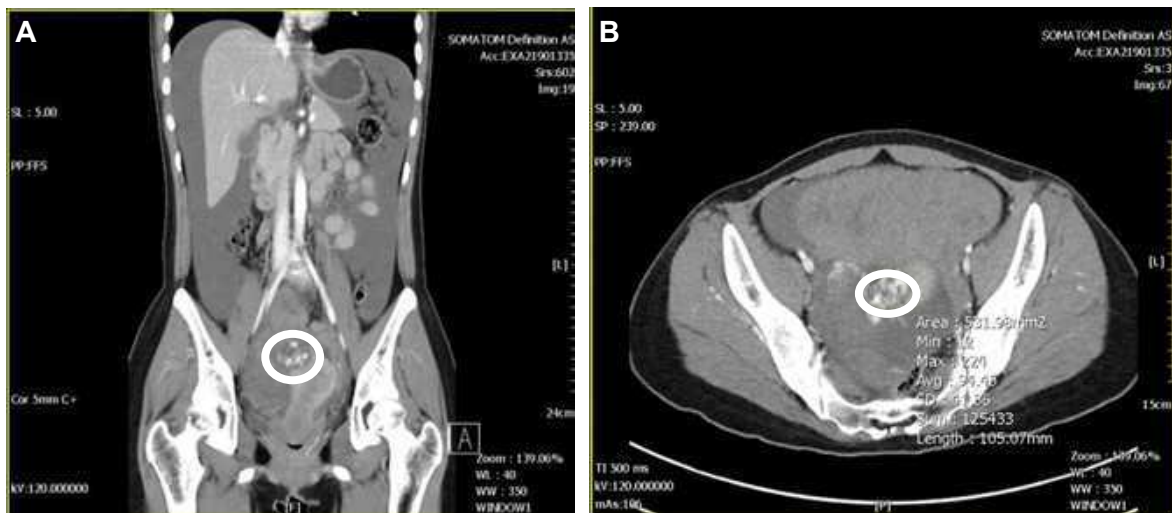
Computed tomography with contrast. (A) Coronal view revealed a right parametrial mass about 3.5 cm in size with large volume of hemoperitoneum; (B) Transverse view showed a right parametrial mass 3.5 cm in size. Circle indicated ongoing bleeding.
